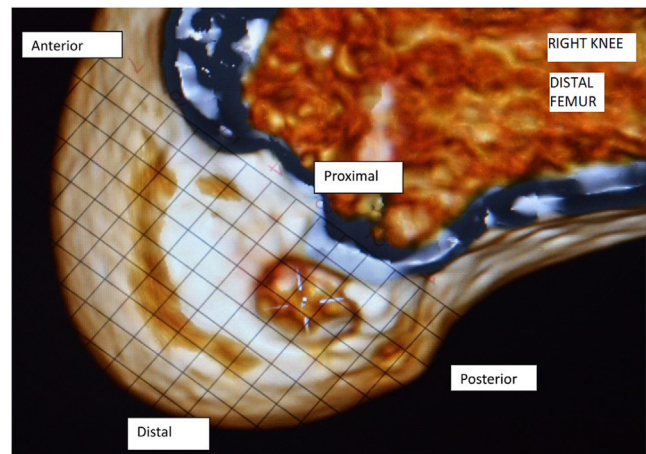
Postoperative 3-dimensional computed tomography of the lateral femoral condyle for evaluation of femoral tunnel position with the superimposed grid of Bernard et al.¹⁵ so as to quantify tunnel position as per the recommendation of Bird et al.¹²
